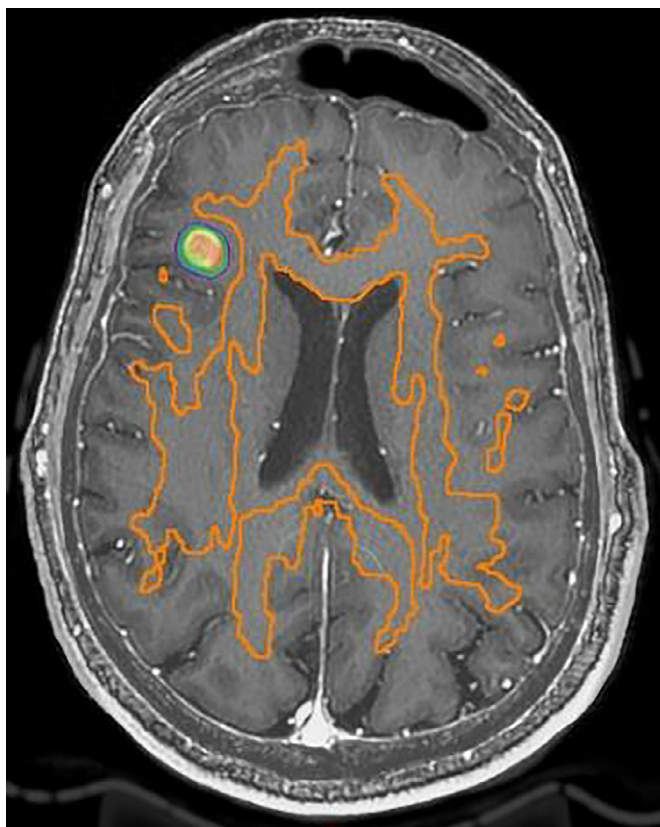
Axial T1+c MRI slice with right frontal brain metastasis in a patient with metastatic breast cancer. Stereotactic radiosurgery (SRS) dose shown in colorwash; white matter tracts for avoidance shown in orange.
